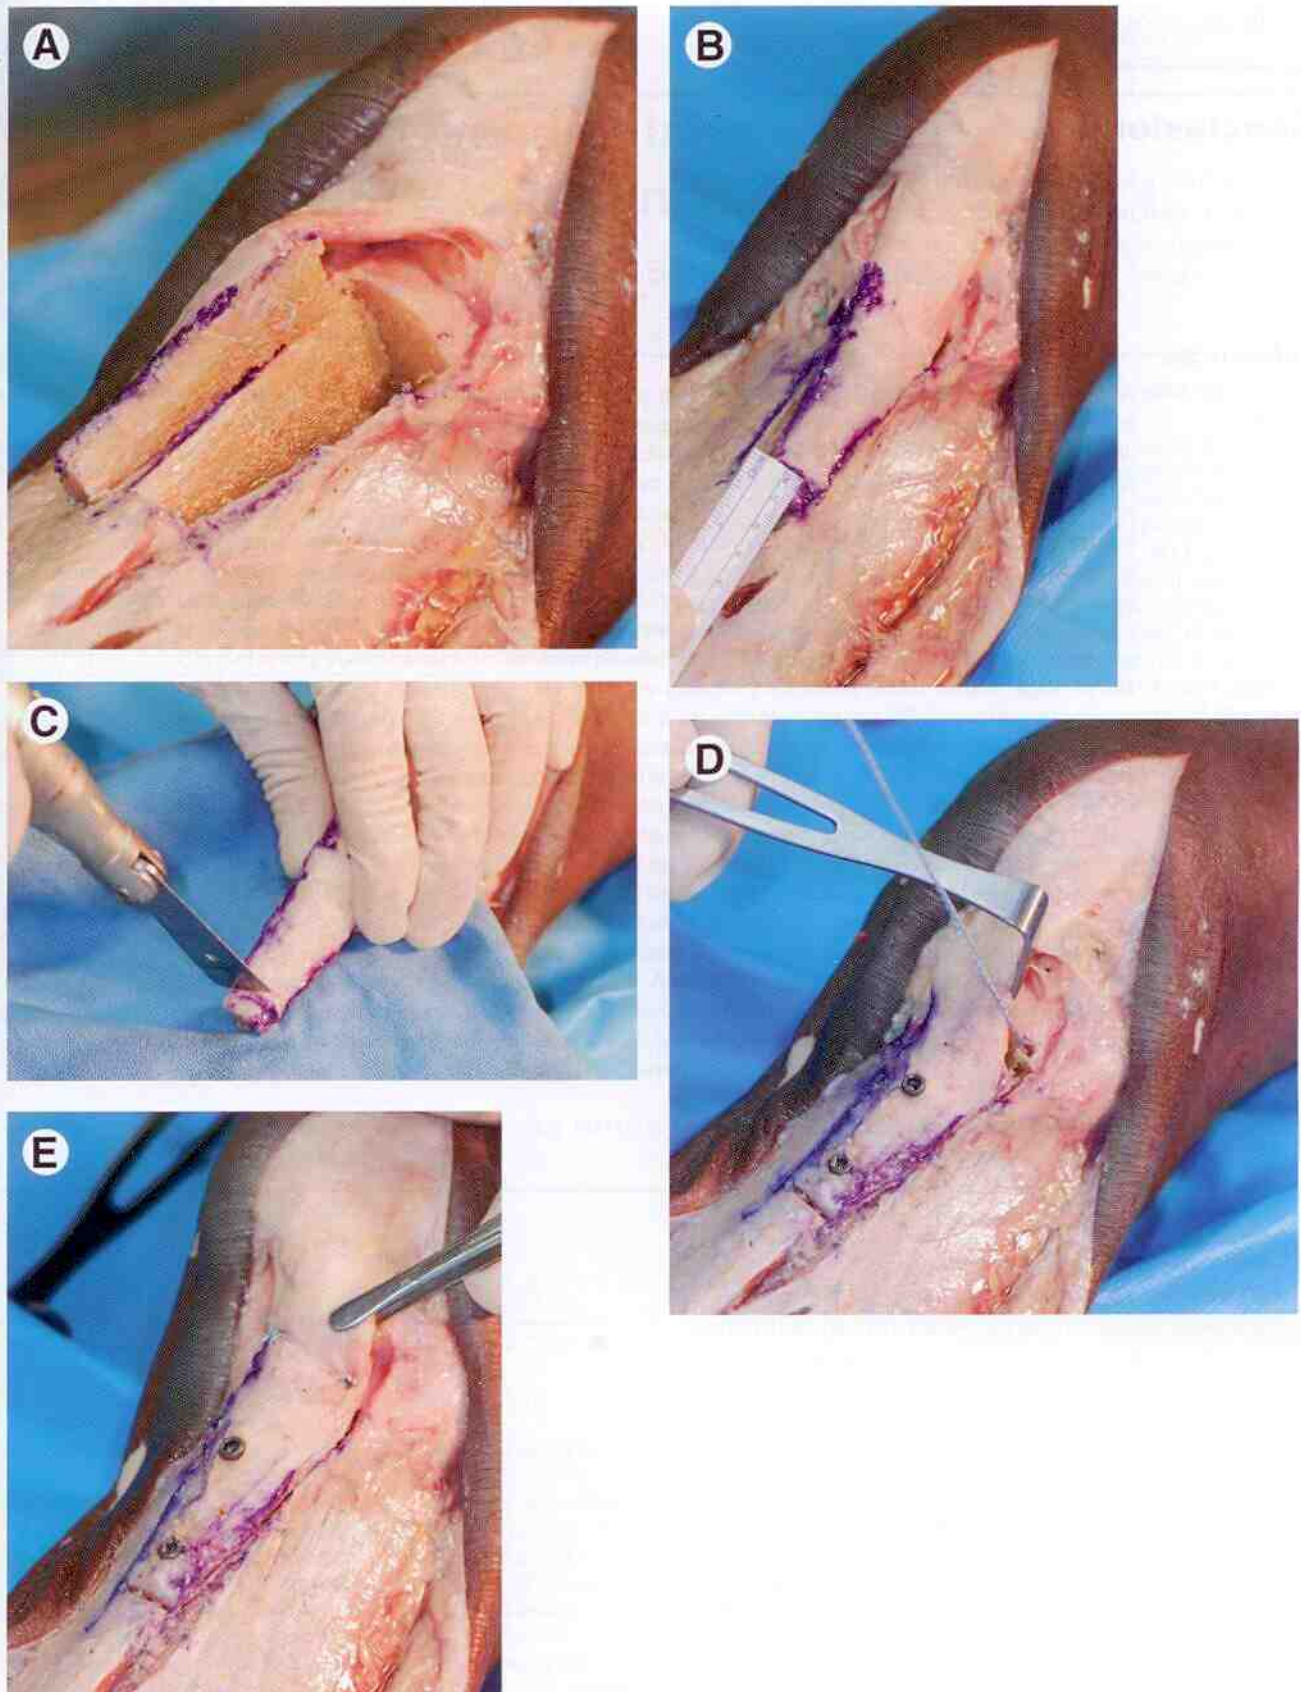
(A) Tuberosity and medial and lateral aspects of patellar tendon freed. (B) Distal cut is measured based on preoperative measurements from magnification corrected radiographs. (C) Distal cut made with saw. (D) Tibial tuberosity is distalized and fixed with 2 4.5 mm screws. Option of tenodesing the tendon at the original attachment site. (E) Tenodesis of patellar tendon at the original attachment site with 2 suture anchors.
